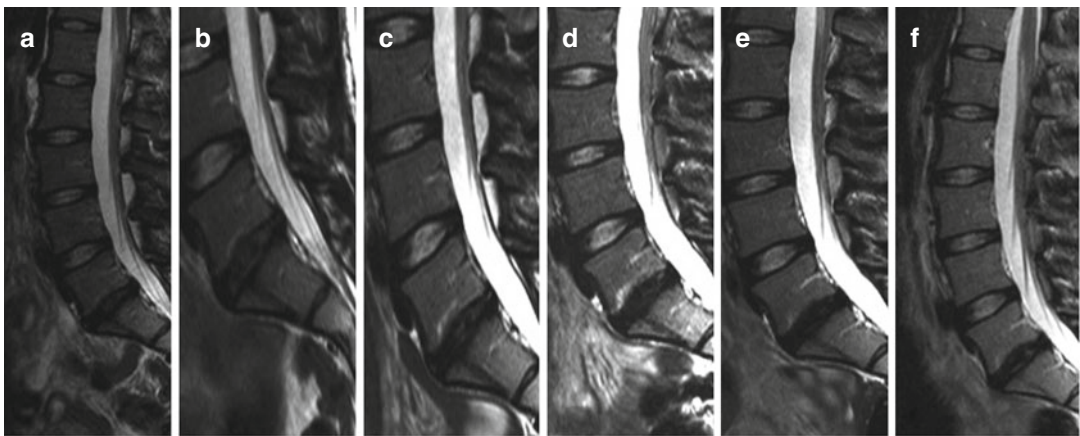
A 28-year-old woman undergoing diskectomy in level L5–S1. The 60-month follow-up MRI displays increased signal intensity in the transplanted L5–S1 level. (a) Pre-transplantation. (b) 1 day post transplantation. (c)
